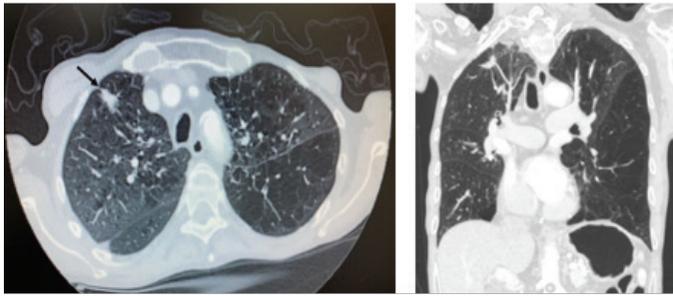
Mass detected in the upper lobe of the right lung on thorax CT
